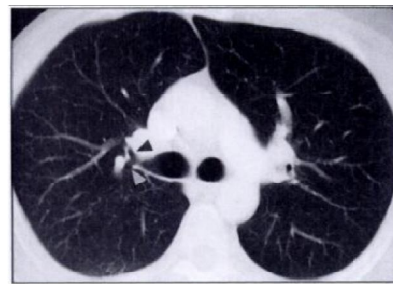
Tracheal bronchus – CT aspects (3).
